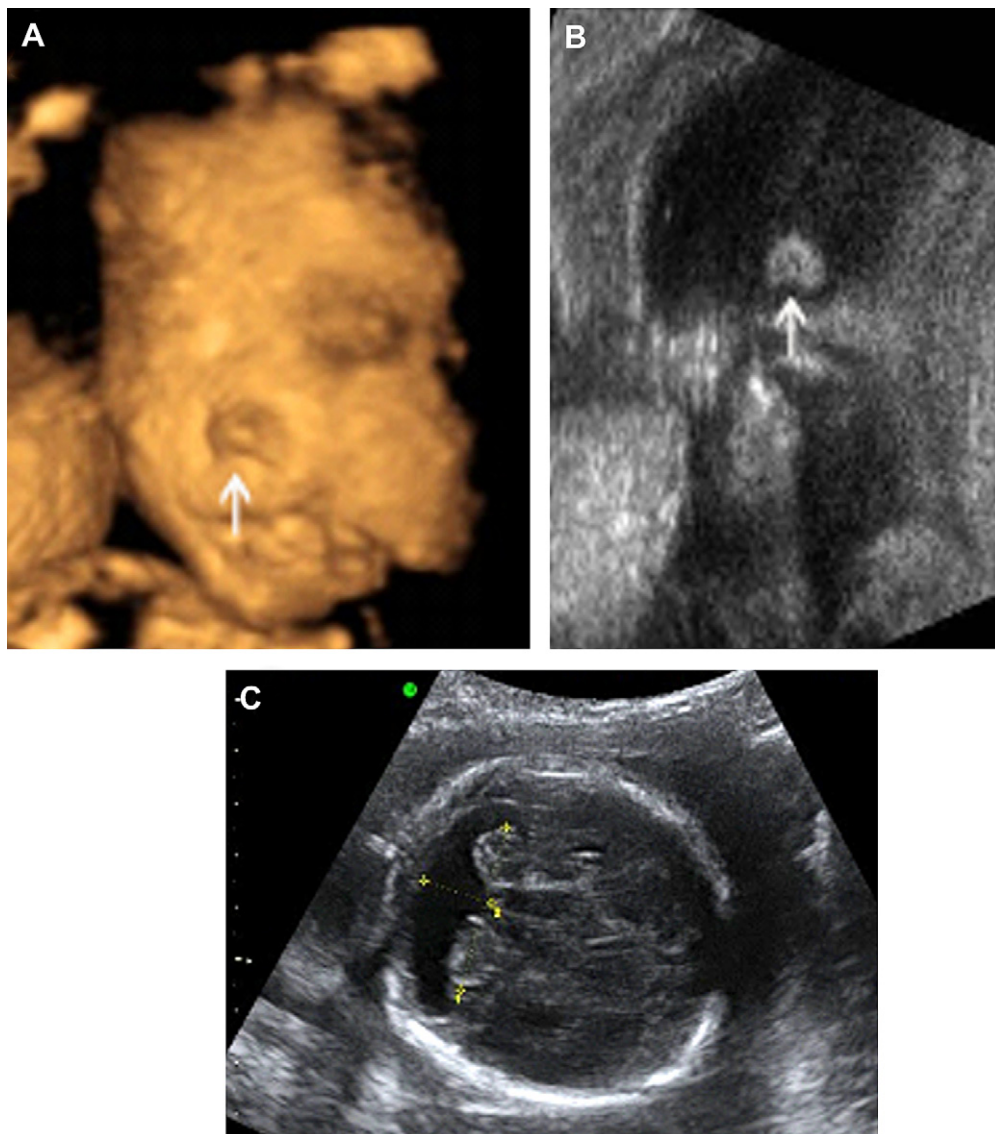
Prenatal ultrasound of Case 1 at 25 gestational weeks shows cebocephaly with a single nostril (arrow) on (A) three-dimensional ultrasound, (B) two-dimensional ultrasound, and (C) semilobar holoprosencephaly.
